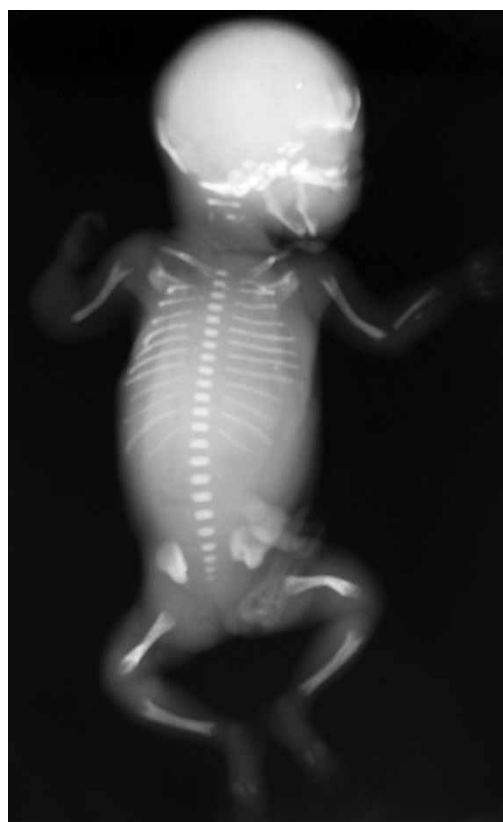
Roentgenogram of the fetus with perinatal hypophosphatasia shows findings typical for hypophosphatasia. The overall shape is much more preserved than the ossification. The upper limbs show defective ossification of the left ulna and right radius and ulna. The spine shows skipped ossification of the cervical vertebrae and no ossification on the pedicles. The femurs are slightly bowed, while the tibiae are straight and of normal length. The femurs, tibiae and humeri show V-shaped metaphyseal defects very typical of hypophosphatasia.
